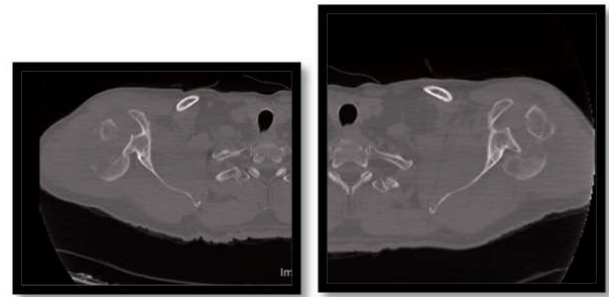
CT image showing intact articulate surface of humeral head
